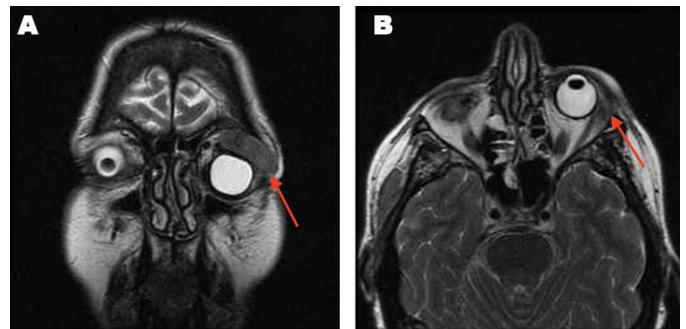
(A, B) MRI orbit face and/or neck without contrast, largest mass located in left temporal region demonstrated by red arrows (Photo Courtesy of Dr. Barry F. Riggs).
